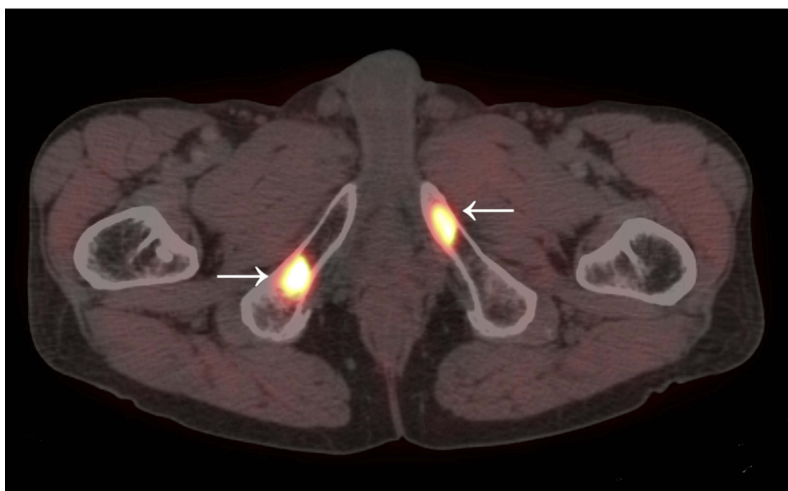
Positron-emission tomography-computed tomography. Hot spots within the os pubis can be seen.
